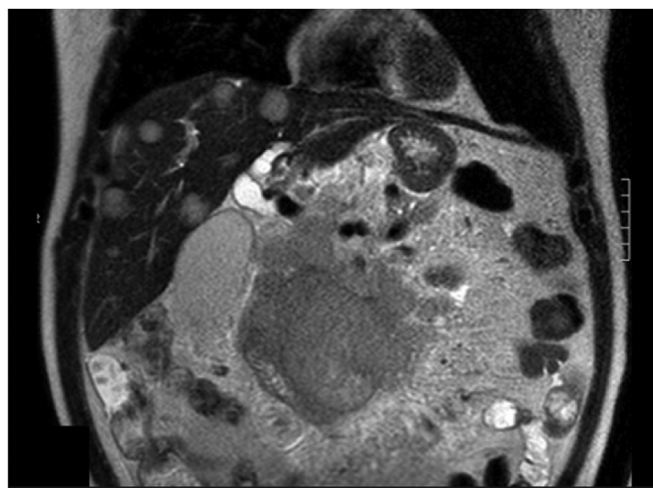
CT image with pancreatic neuroendocrine tumor and liver metastases.
